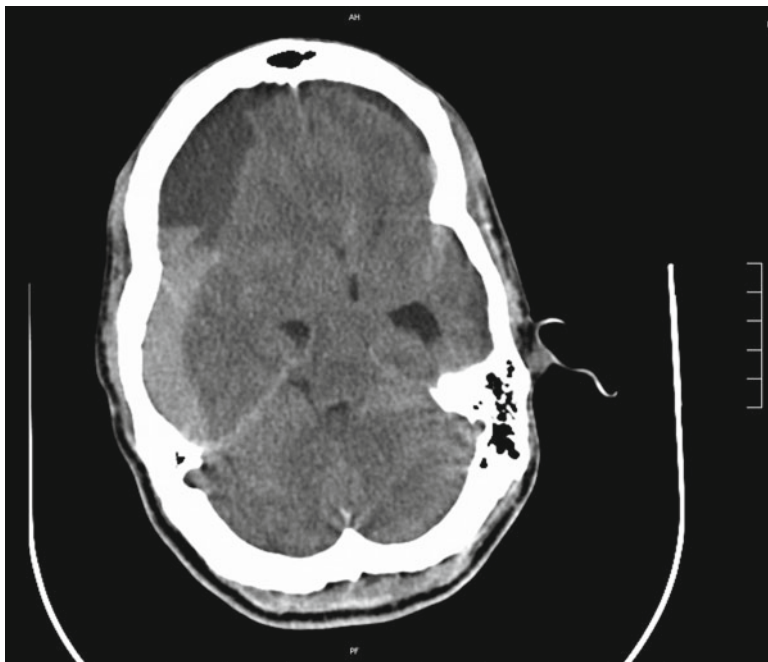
CT brain scan in a patient with late stage HD and multiple falls. There is a chronic subdural hematoma over the right side of the brain with mass effect and midline shift. This hematoma required multiple surgeries and was ultimately fatal
